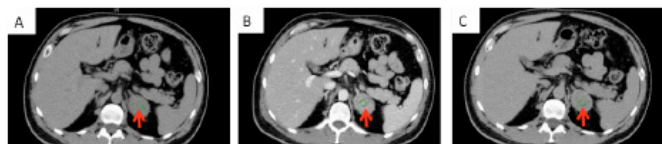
Computed tomography of abdomen confirming a 4 x 4 cm left adrenal mass on axial view. A: Precontrast view, 40 HU; B: Postcontrast view, 83 HU; C: Washout seen with 15 minute delayed view with contrast, 52 HU
